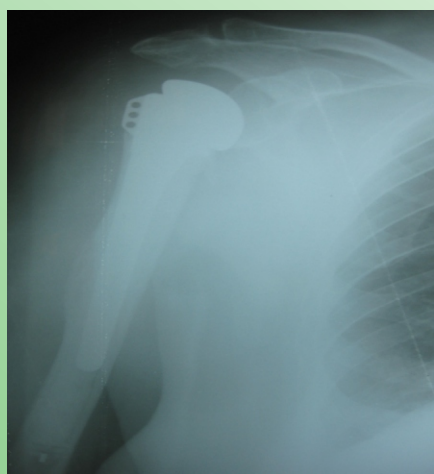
Antero-posterior Radiograph at 2-year Follow-up.
